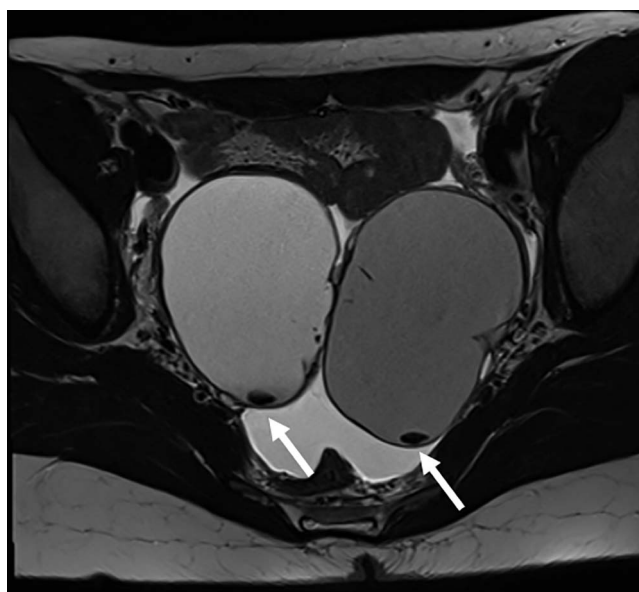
T2-weighted image depicting bilateral intermediate/hyperintense ovarian lesions with the left lesion being slightly more hypointense compared with the lesion in the right ovary. T2w-hypointense nodule at the base of both lesions (white arrows).
